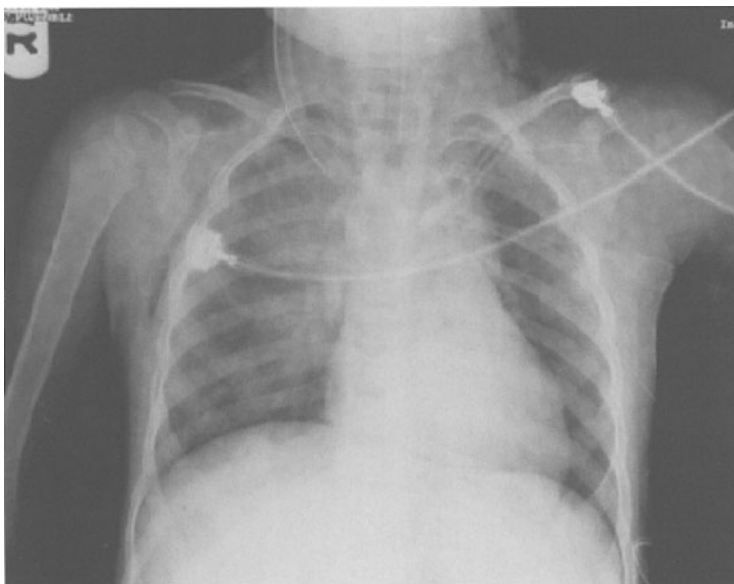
Chest x-ray of severe asthma in adolescent boy. Lungs are over inflated and hyper transparent, diaphragm and ribs are flattened, heart is reduced in volume due to external compression.
